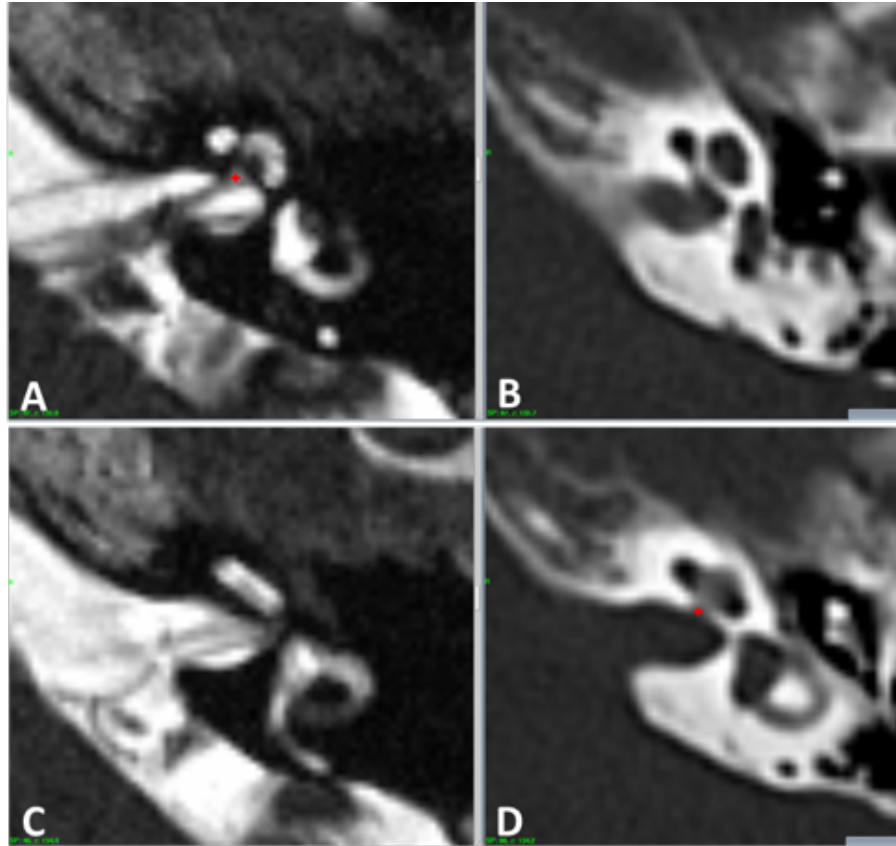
Discrepancy between MRI and CT imaging planes causing overestimation of the difference seen in the outliers (case 33). A. The red cross shows an acceptable coordinate measure of the location of the cochlea in the pre-GKR MRI scan (x, y, z : 127.1, 99.5, 135.9). The next MRI slice does not show the cochlear aperture (C). The images in the right show the cochlea bisected at two levels by the CT scan, one closer to the top (D) and the second closer to the bottom of the cochlea (B). The CT measurements for the study (x, y, z : 127.6, 99.5, 134.2) were taken from the superior slice (D) overestimating the difference in the z axis by the same magnitude as the slice thickness.
